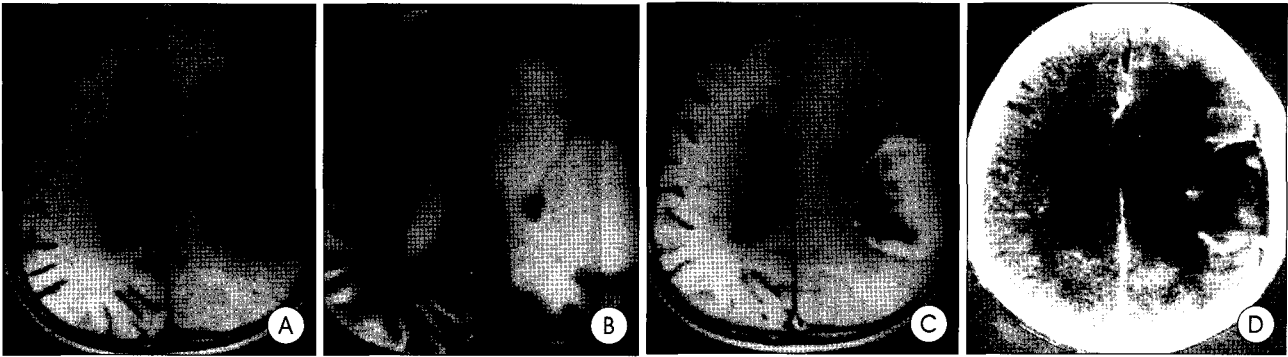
Magnetic resonance imaging showing a intracranial mass attached to the left temporoparietal convexity margin of 5.5×4.5 cm in size with peritumoral edema and mid line shift (A and B). The mass heterogeneously enhancing after intravenous contrast injection (C). Gross total removal of the tumor mass and dura mater (Simpson grade I) is achieved with meticulous bleeding control (D).
